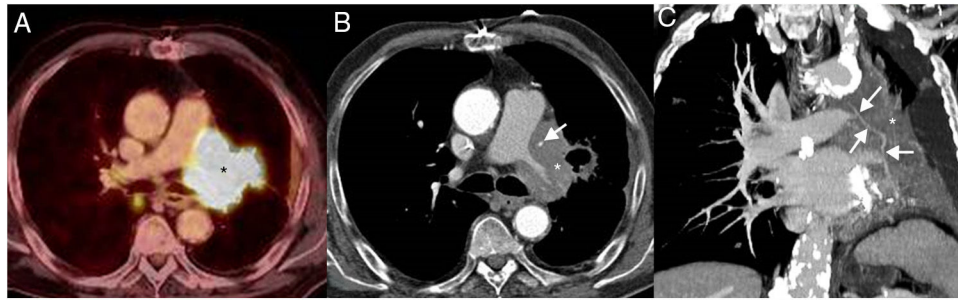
Axial fused PET/CT image (A) demonstrates a hypermetabolic mass (asterisk). Axial CT image (mediastinal window) from the CT portion of the PET/CT (B) study shows an increase in the size of the left hilar mass (asterisk) and a greater secondary encasement of the left internal mammary artery graft (arrow) with respect to the previous imaging study. Coronal CT image (mediastinal window) from the CT portion of the PET/CT (C) better depicts the encasement of the coronary artery bypass graft (arrows) by the mass (asterisk).
